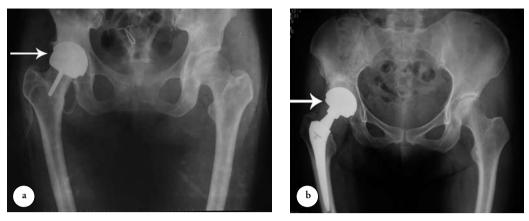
a) Anteroposterior radiograph of the pelvis of a patient who underwent resurfacing hip arthroplasty on the right hip at one year postoperatively. b) Anteroposterior radiograph of the pelvis of a patient who underwent bigfemoral-head total hip arthroplasty on the right hip at one year postoperatively.
